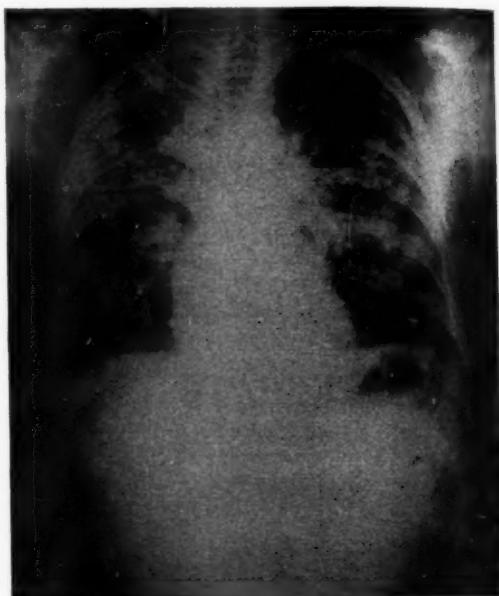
Photograph of x-ray of lungs in case of pneumo-silicosis.
